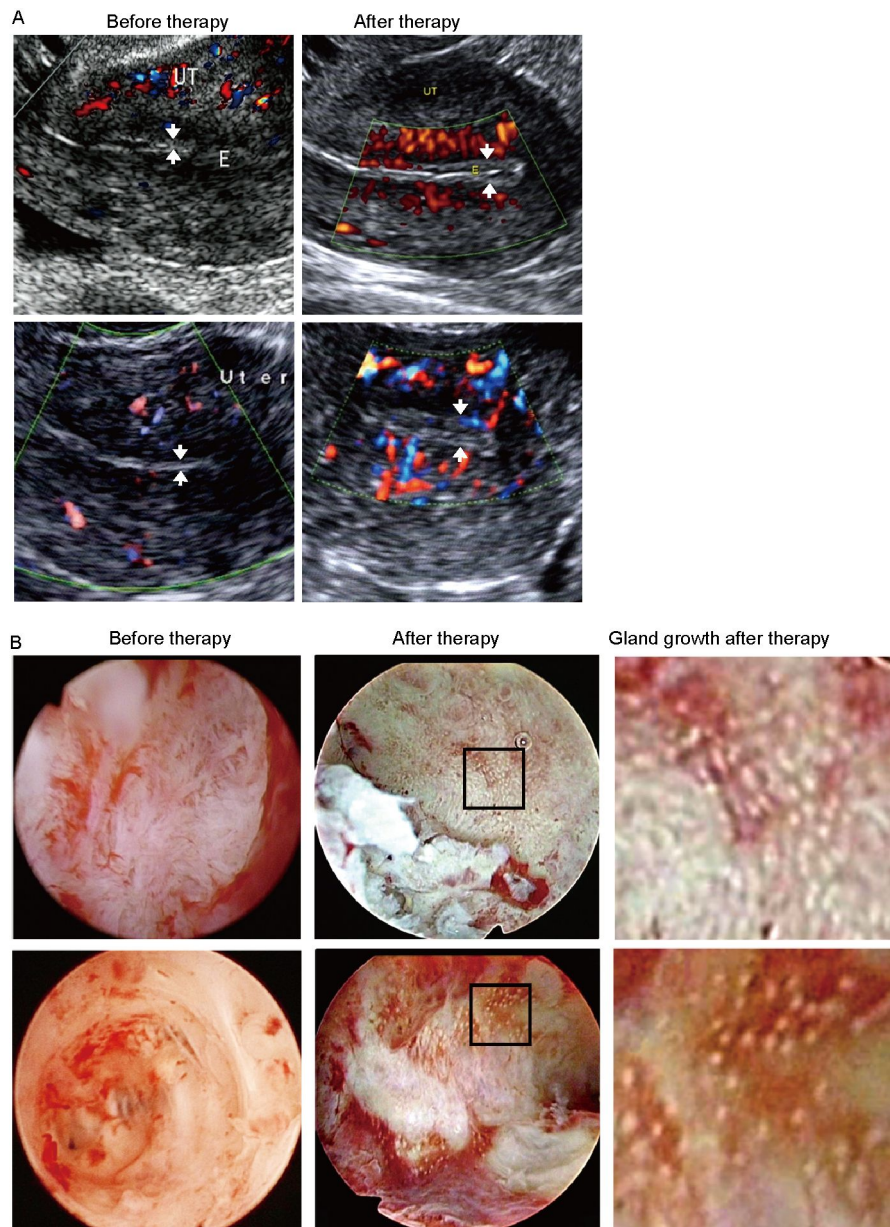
Hysteroscopic and ultrasound images of the uterus. A, The ultrasound scans show the pre- and post-therapeutic endometrial thickness and blood flow in the uteri from patients with severe AS. The white arrow shows the endometrium. B, Pre- and post-therapeutic hysteroscopic images of patients with AS. The arrows show the oviduct aperture.
